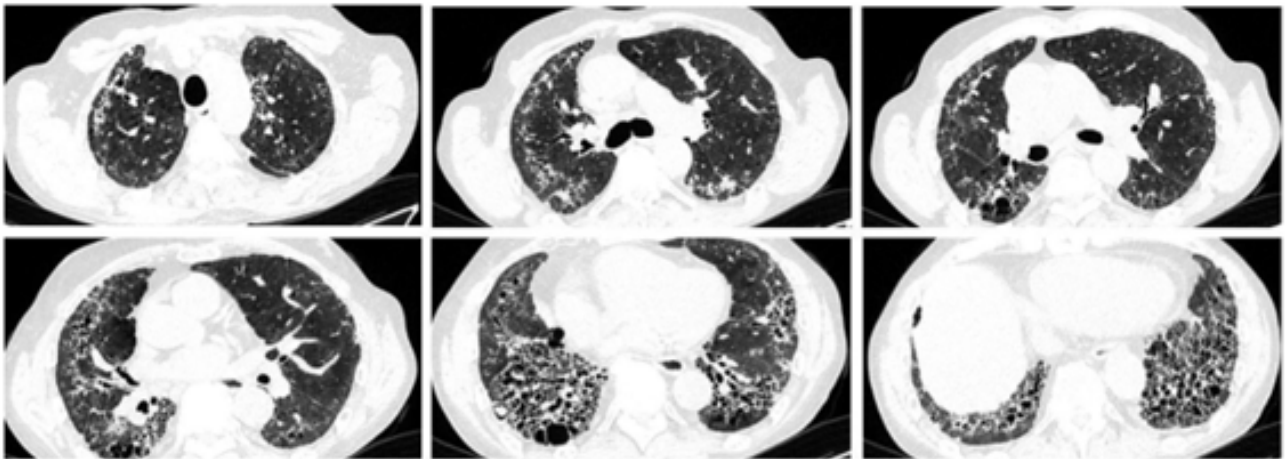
Axial HRCT images from 2024. showed further progression, first interpreted as honeycombing.
